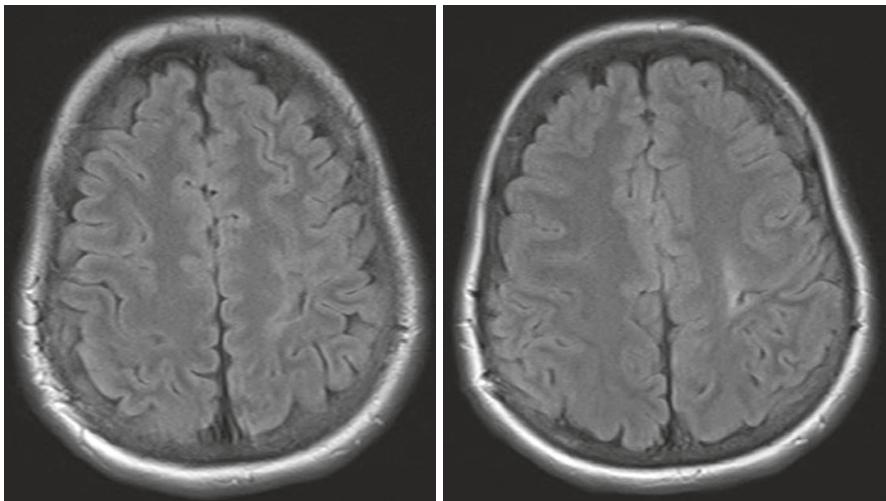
Axial T2 FLAIR images of a 32-year-old woman with a history of drug-resistant epilepsy. Subtle asymmetric T2 hyperintensity with blurring of the gray-white differentiation and associated deep sulcus involving the left precentral gyrus suggests focal cortical dysplasia. (Image courtesy of Dr. Lilit Mnatsakanyan)
